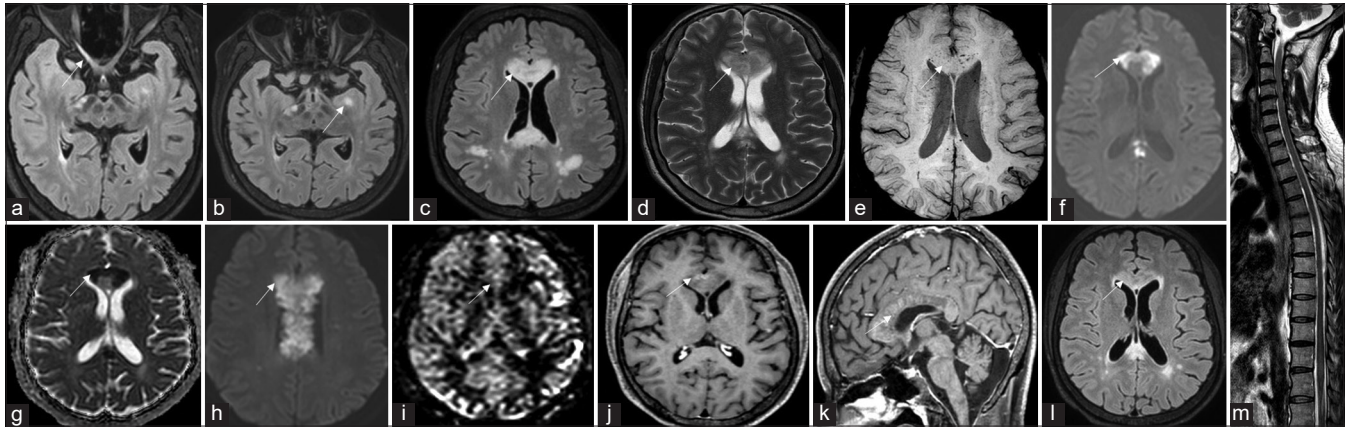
34-year-old male presented with the right optic neuritis and pyramidal signs as described above, magnetic resonance imaging (MRI) acquisition with axial reformats reveals fluid-attenuated inversion recovery (FLAIR) hyperintensity in the right optic nerve (arrow in a), multiple rounded lesions in the bilateral medial temporal lobe and bilateral parietal lobe (arrow in b). Diffuse, expansile T2-FLAIR hyperintensity (arrow in c and d) is noted involving genu, body, and splenium of corpus callosum. The lesion shows foci of microhemorrhages as blooming on susceptibility weighted imaging (arrow in e), along with central facilitated diffusion (red arrow in f and g) and peripheral restriction in the corpus callosum lesion (white arrow in f-h). Base image of arterial spin labelling shows no raised perfusion (arrow in i). Patchy peripheral enhancement is seen on post-contrast images (arrow in j and k). Follow-up MRI Scan after 1 month reveals significant resolution in the corpus callosum lesion. Whole spine MRI screening T2 acquisition in sagittal reformat (arrow in l) (m) reveals no abnormal signal hyperintensity in the cord.
